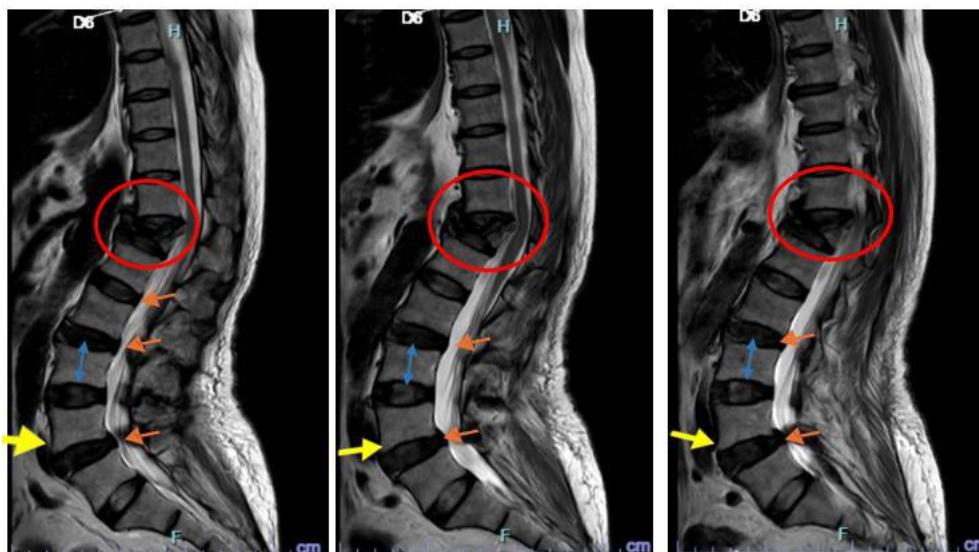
MRI Sequences (eSag_T2-TSE) red marking indicates D12 vertebral collapse with yellow marking indicating anterolisthesis. Orange marking signifies Disc desiccation and blue indicating spondylotic changes.
